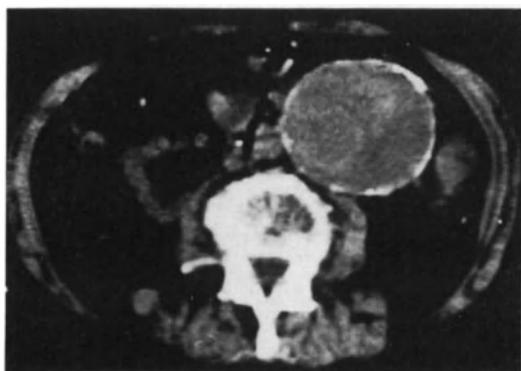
CT of large abdominal aortic aneurysm with calcified wall.
